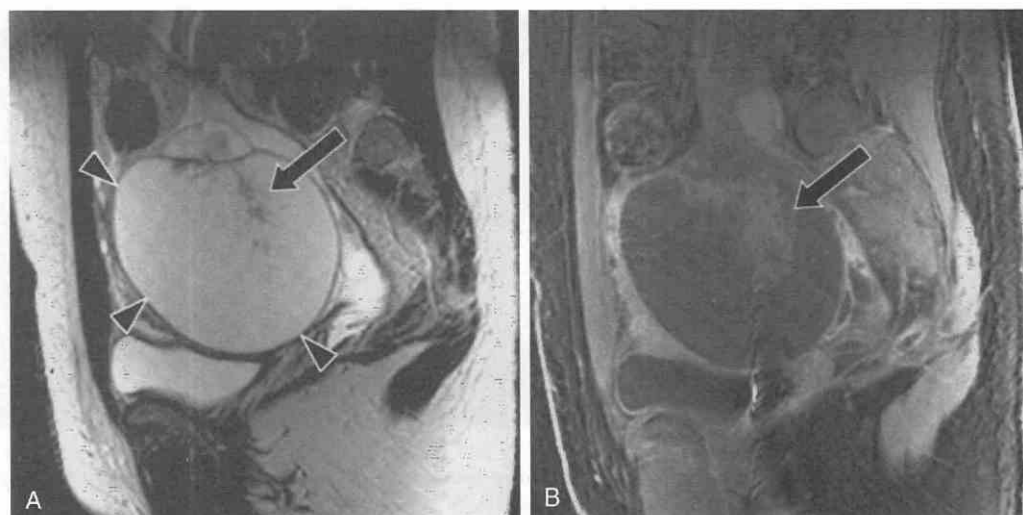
Papillary projections in a patient with a borderline ovarian serous tumor. *A*, Sagittal T2-weighted, fast spin-echo image (TR = 6000, TE_{eff} = 119) shows a multicystic left adnexal mass (arrowheads). Within this mass is an ill-defined projection with a low-signal-intensity core (arrow). *B*, Sagittal T2-weighted, fat-saturated, gradient-echo image (TR = 250, TE = 2.9) shows enhancement of the papillary projection (arrow). Many of the papillary projections show very high signal intensity, blending in with the fluid within the cyst in *A*. TE_{eff}, effective echo time.
